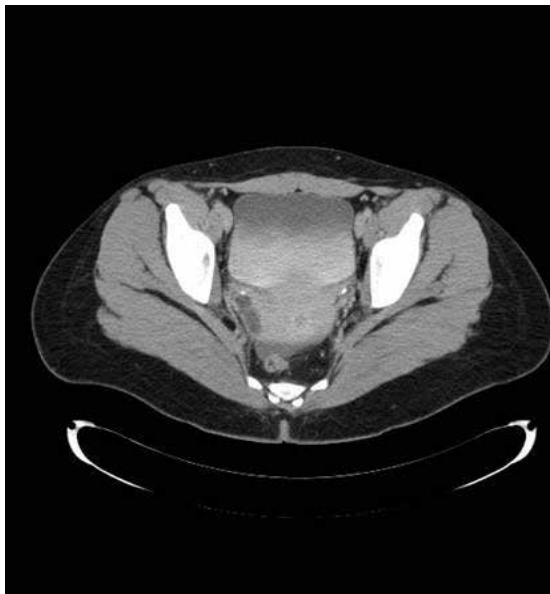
Infraspinteric urinary leakage shown by contrast CT urography (arrow).
